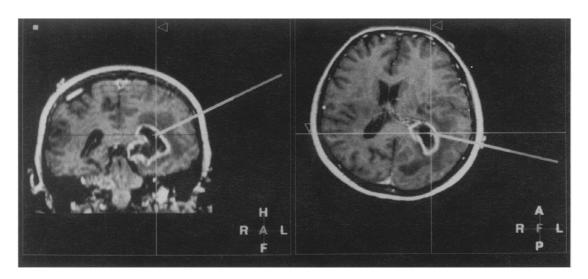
'Frameless' interactive stereotactic biopsy of a deep left parieto-occipital glioma, intra-operative coronal and axial MR images from EasyGuide. The pointer is held above the burr hole in a specially designed adjustable biopsy arm, and by 'virtual elongation' of the tip length the exact trajectory and depth to the tumour can be determined. The pointer is then replaced by the biopsy needle that passes to the tumour along this trajectory through the guide of the biopsy arm.
